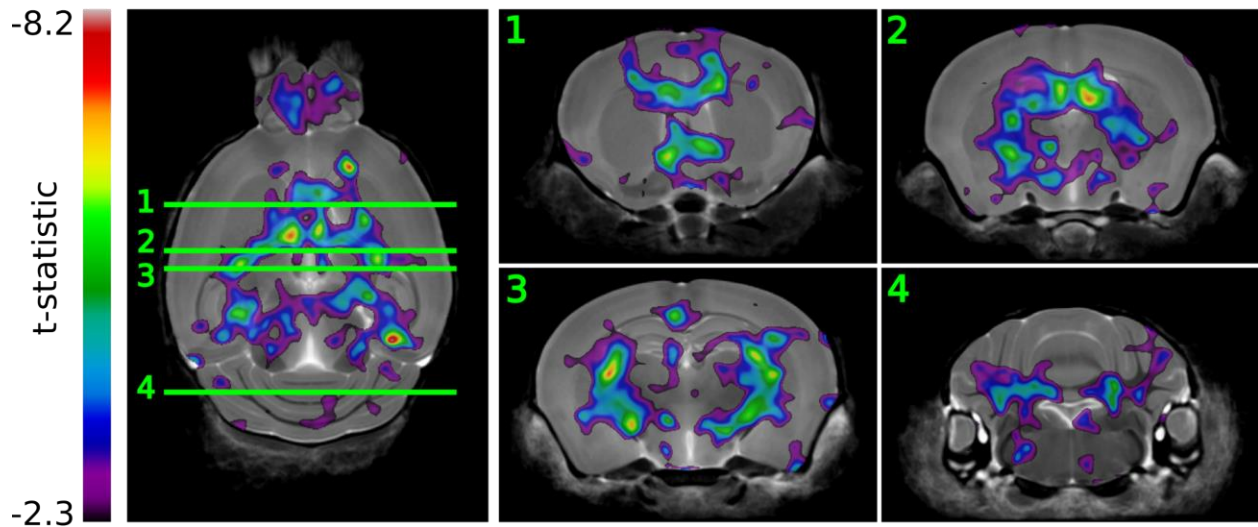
Mapping of the impact of cranial radiation over the whole brain is shown. A color overlay on top of an average MR image shows regions of significant volume decrease as a t-statistic. Radiation (7Gy) was delivered at postnatal day 16. The brain phenotype is depicted at 6 weeks of age.
